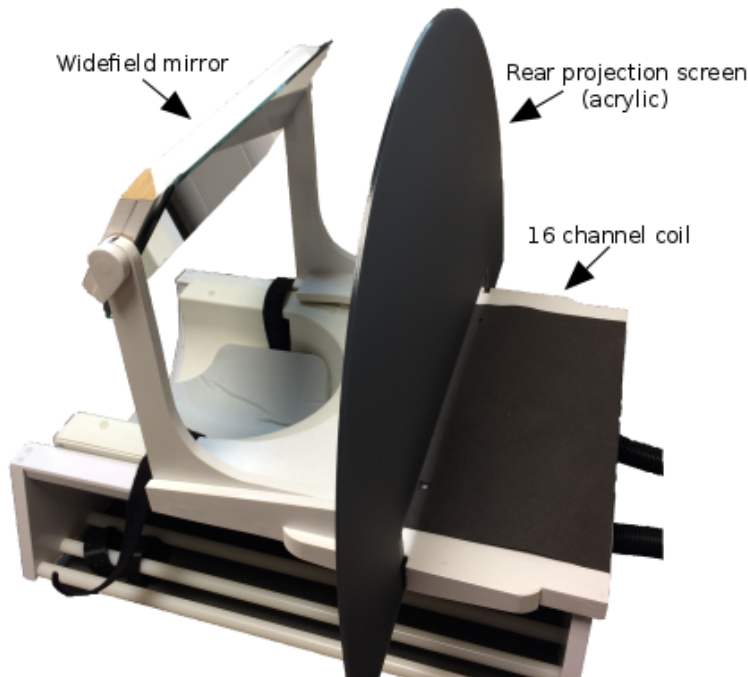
A photograph of the MRI data acquisition set up. A custom made acrylic screen and wide angle mirror are slotted on the 16 channel Nova Medical half-head posterior coil.
